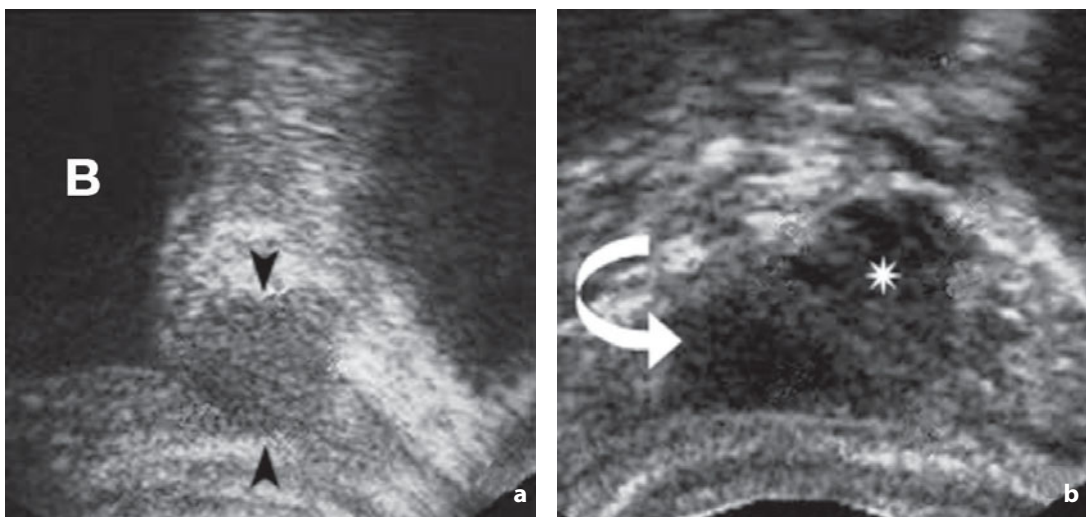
Ultrasonography. Local recurrence following radical prostatectomy. a The *arrowheads* in the longitudinal scan indicate a hypoechoic nodule at the level of the vesicourethral anastomosis. b The *asterisk* in the axial scan of another patient indicates the presence of a hypoechoic lesion with ill-defined margins located to the left of the vesicourethral anastomosis (*curved arrow*). B, urinary bladder
